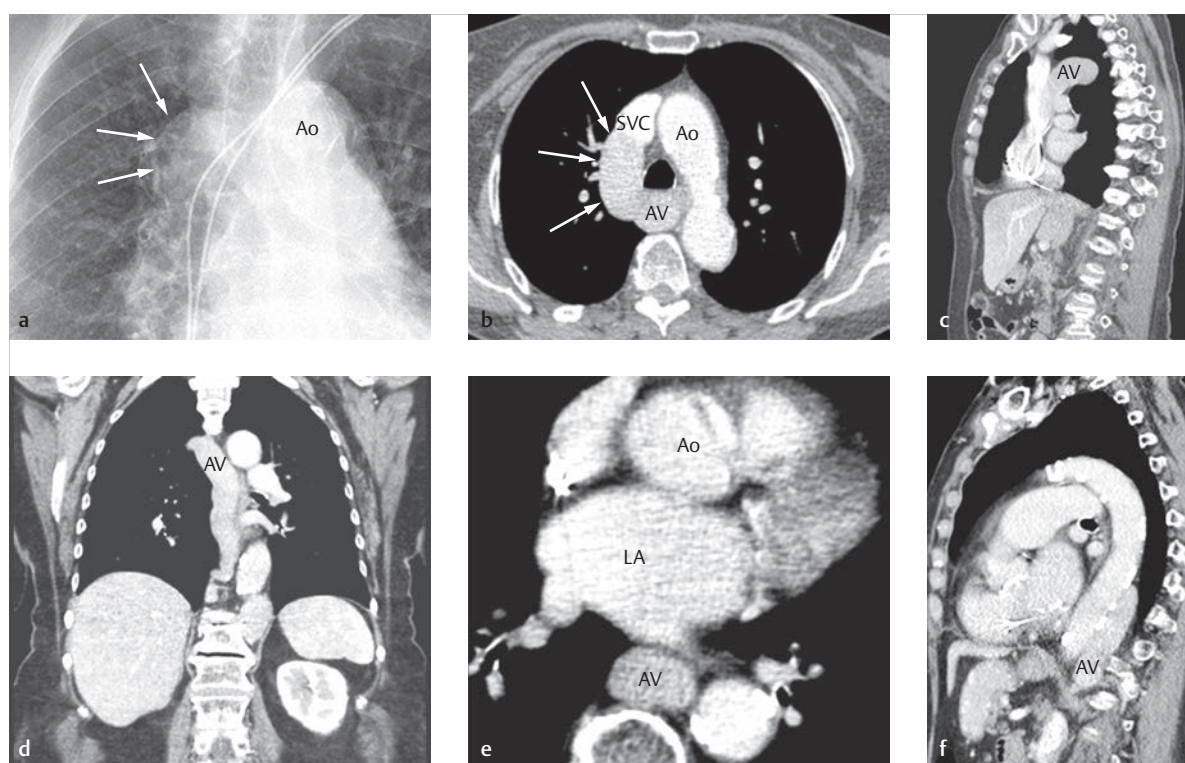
Azygos continuity and absent inferior vena cava. Eighty-year-old female patient. The azygos continuity connects to the superior vena cava (a–c). The connection can be seen clearly both in the thoracic X-ray (a, arrows) and in CT (b, arrows).
